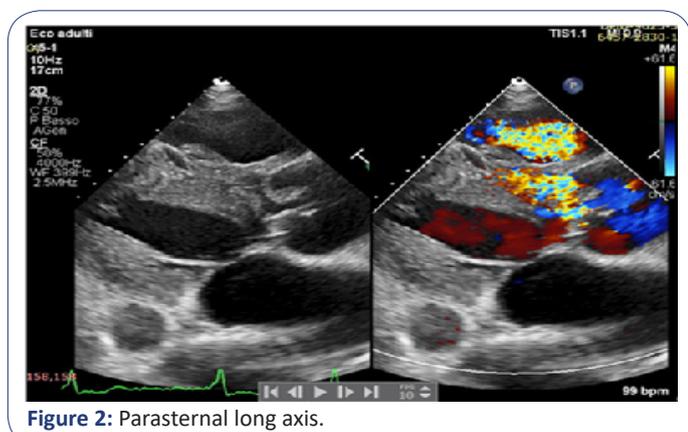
Parasternal long axis.
